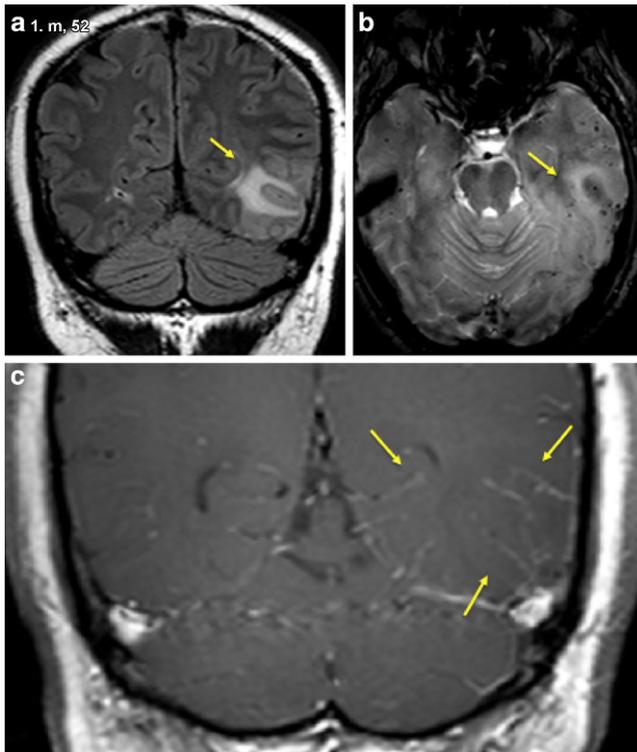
52-year-old man with CAA-related inflammation (case 1). Coronal FLAIR (a) imaging with multifocal subcortical oedema with U-fiber involvement (*yellow arrows*), axial susceptibility-weighted (b) imaging with multiple bilateral cortical-subcortical microbleeds (*yellow arrows*), and coronal contrast-enhanced spin-echo T1-weighted (c) imaging with faint leptomeningeal contrast enhancement (*yellow arrows*)
